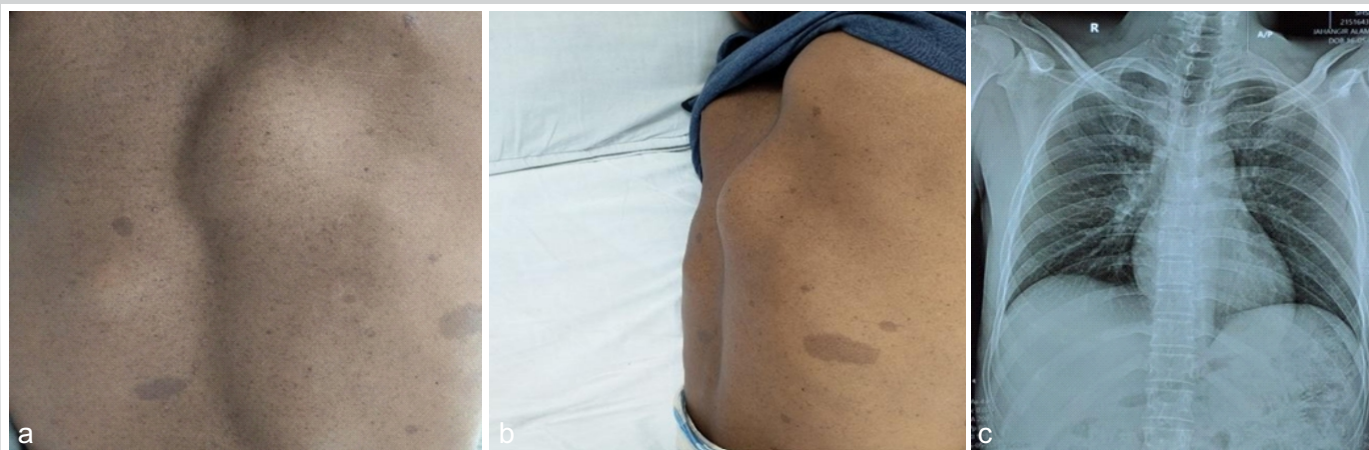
(a) Tumor is visible with a café au lait spot of Back view, (b) Tumor is visible with café au lait spot of Side view, (c) Pre-operative Dorsal Spine Xray represents Osteolytic lesion in costovertebral region of right 7th Rib.
